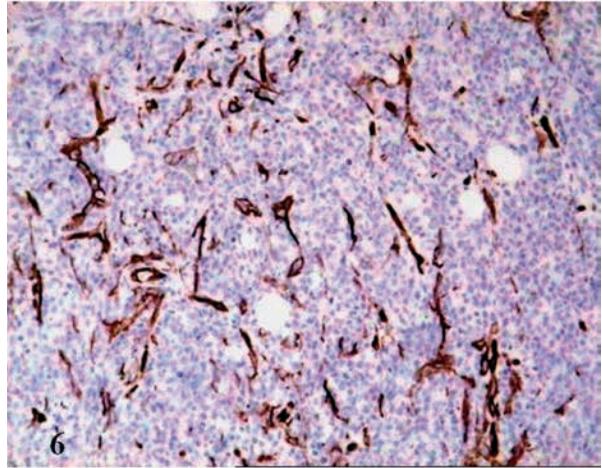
High microvessel density corresponding to the high vascularity by ultrasonography. IP, anti-CD34, OM 100x.
